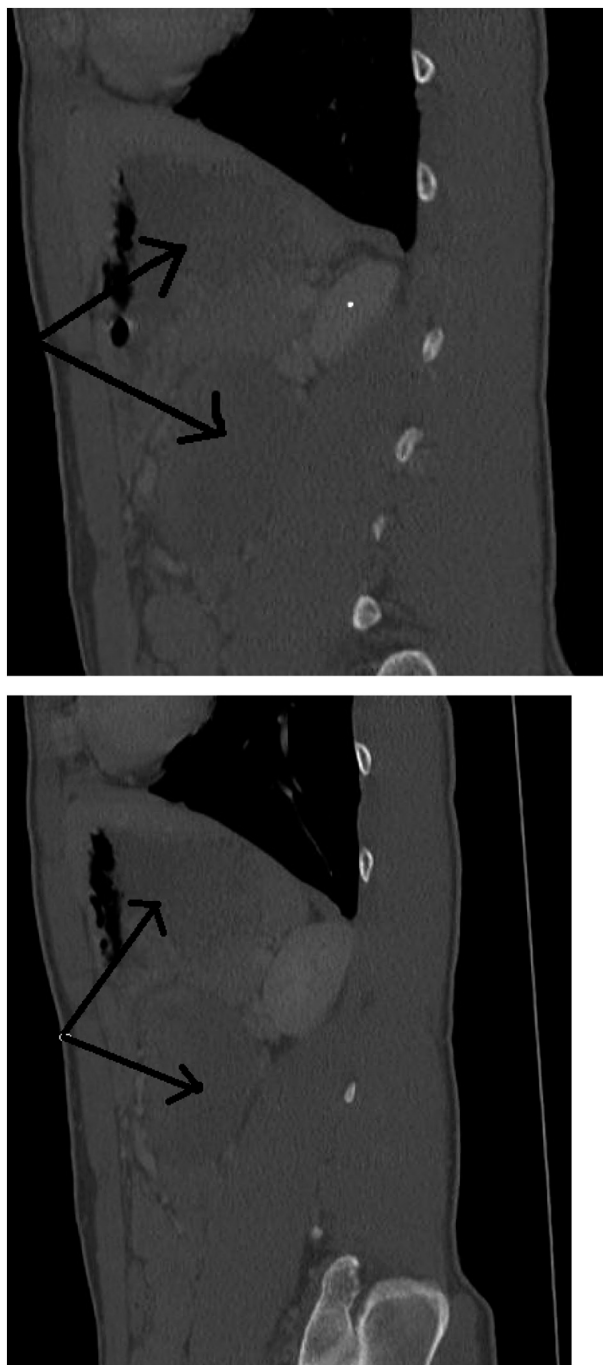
Contrast enhanced CT sagittal view images demonstrating duodenal hematoma.
